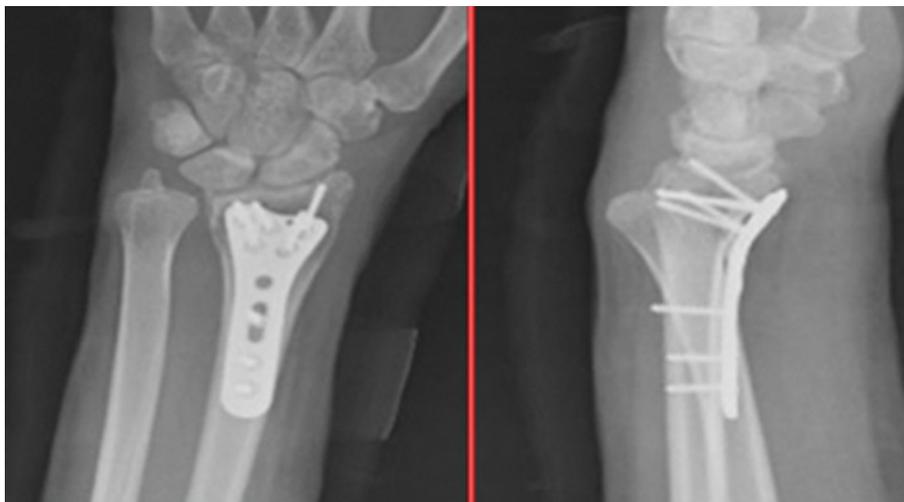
Post-operative X-ray control.
